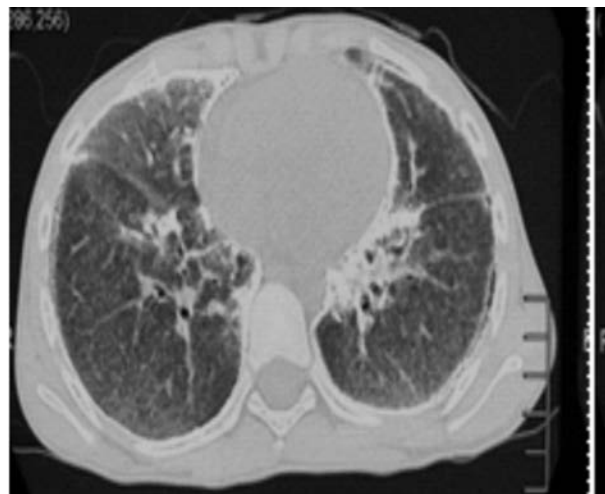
Computed tomography lung window showing calcified micronodule lesions on the midzones with ground glass opacities.
